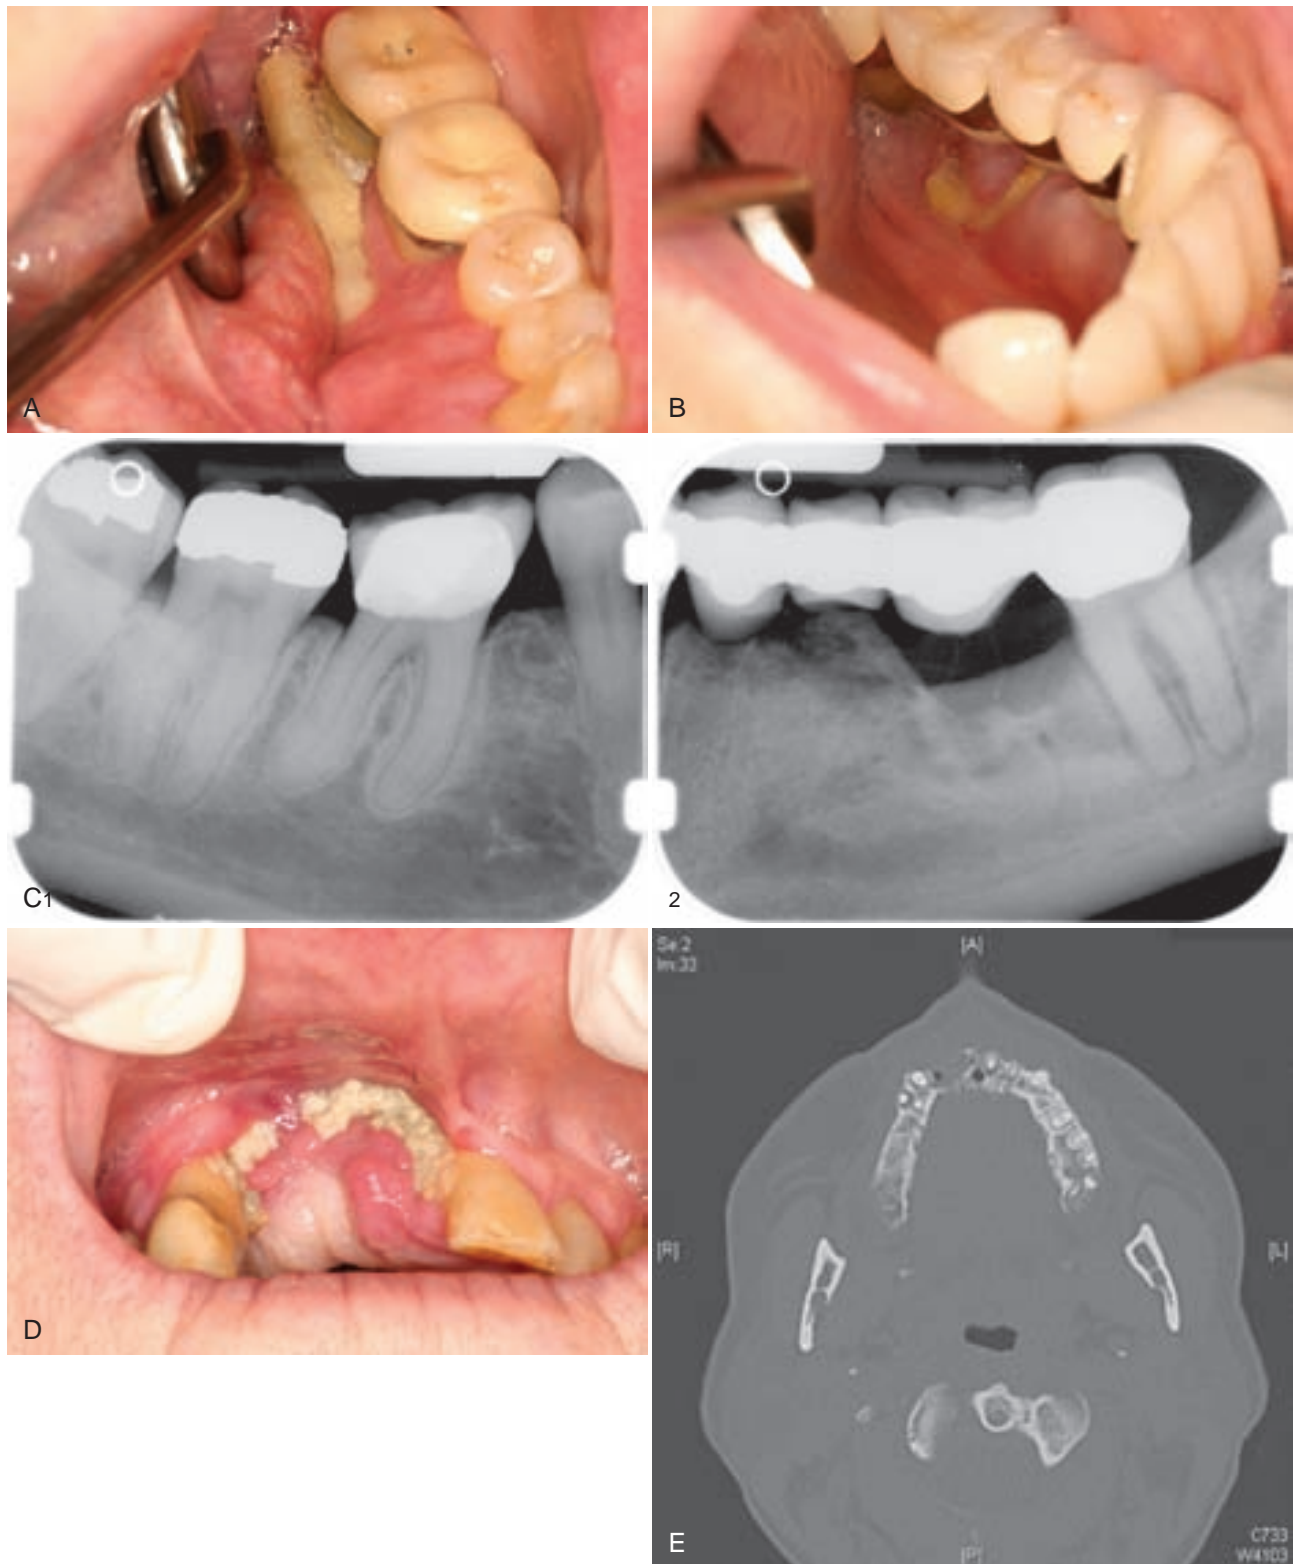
Bisphosphonate-related osteonecrosis. A, Typical exposed sequestrum located on the mylohyoid ridge. B, Sequestrum located beneath a subpontic exostosis. C, Radiograph showing necrotic subpontic exostosis (*right panel*) and teeth with thickened lamina dura on the opposite side (*left panel*). D, Necrotic bone on the anterior maxillary ridge. E, CT scan of patient from part D showing mottled lucency of anterior ridge extending to the palate.
